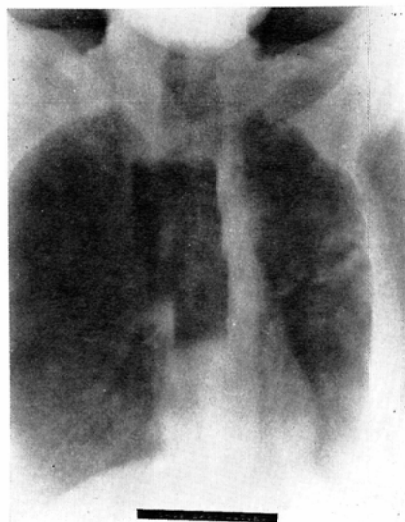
Linacography is carried out to confirm accurate irradiation. This picture taken by 6 MV X-rays.
